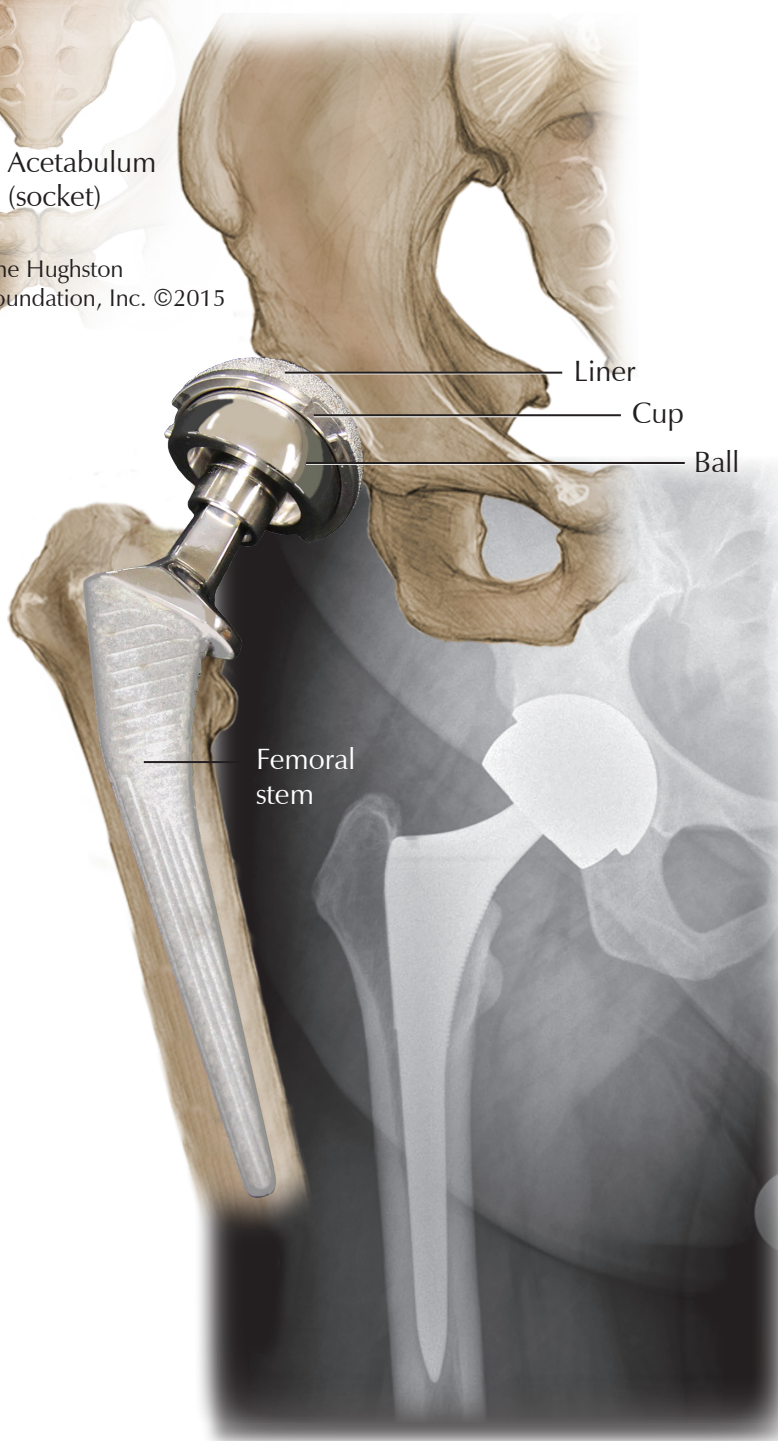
(Left to right) Normal pelvis and femur, total hip replacement with metal-on-metal implant, and x-ray showing a MoM implant
